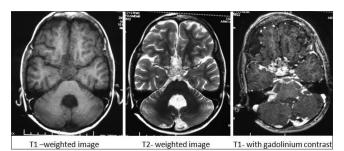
Magnetic resonance image of brain showing diffuse multiple leptomeningeal infiltration in the posterior fossa
